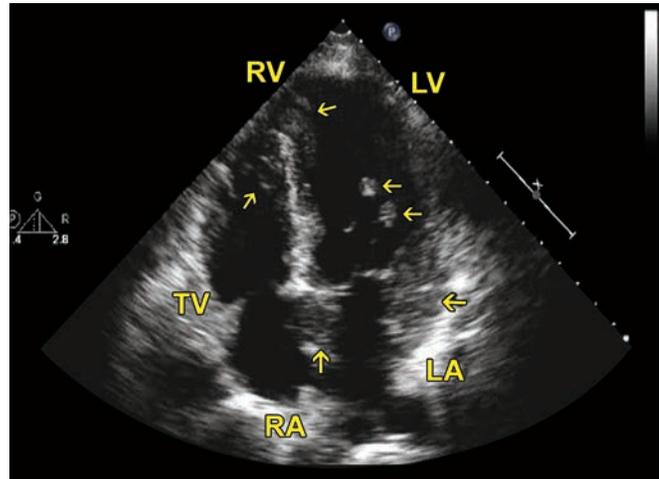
TTE. Apical 4 chamber view showing multiple masses (arrows) in the right ventricle (RV) and left ventricle (LV).
